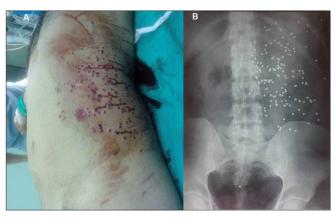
(A) Multiple pellet entrance wounds involving entire left flank; (B) abdominal plain radiography demonstrating multiple pellets in retroperitoneum, abdomen, and one in the pelvis
